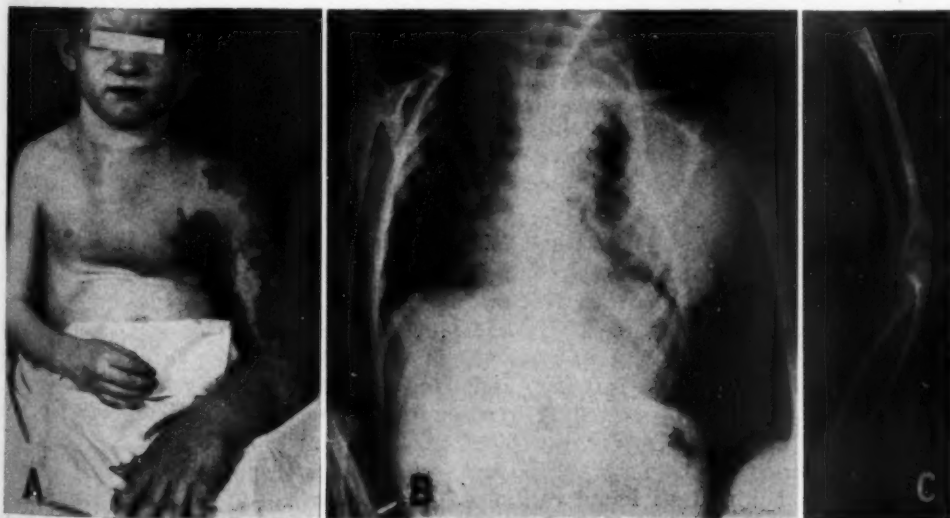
Case No. 439090. A. Hyperpigmentation, overgrowth, and accelerated maturation of left arm and hand of 4-year-old boy. Extension of plexiform neurofibroma (biopsy) into thorax and left side of neck. Lesion, present since birth, was treated by x-ray therapy without response.
